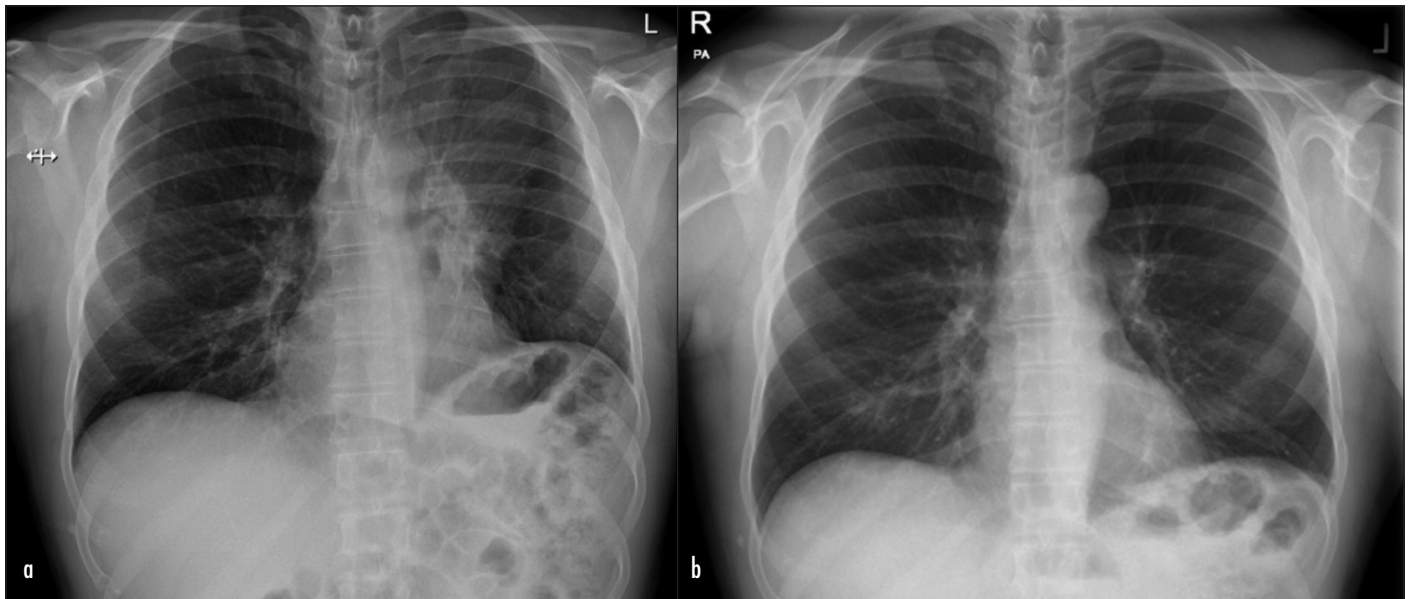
a. Chest radiograph on admission demonstrating the signs of left upper lobe collapse with an apparent left hilar mass and volume loss. b. Normal chest radiograph following treatment.
